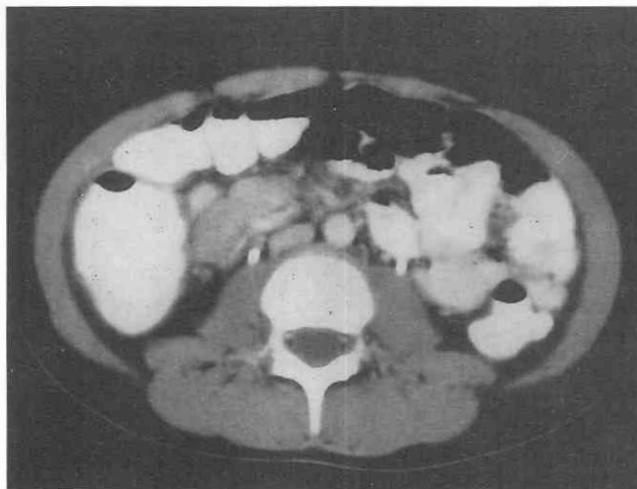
Mesenteric lymphadenopathy. CT scan through the lower abdomen shows enlarged mesenteric lymph nodes in the right lower quadrant.
